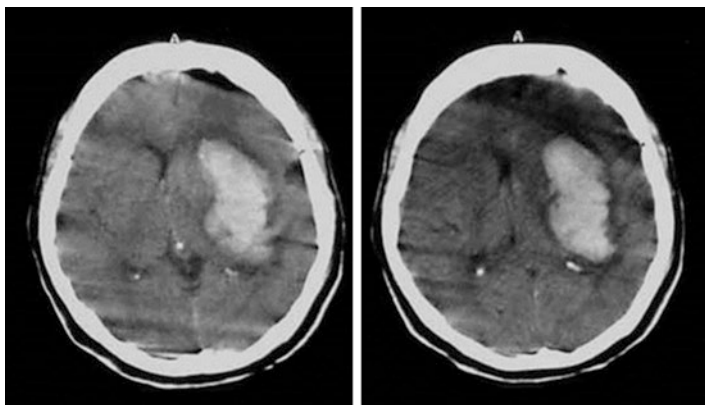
Non-contrast axial CT scan of a 31-year-old male with sudden right hemiplegia and altered level of consciousness, showing a large left basal ganglia/internal capsular hemorrhage. Note the movement artifacts as the patient was restless and not fully cooperative. The lesion is obvious in spite of the artifacts. The quality of the CT image may vary from place to place depending on resources, but the rule of thumb is that “only the best image is good enough for interpretation in order not to miss a small abnormality”!
